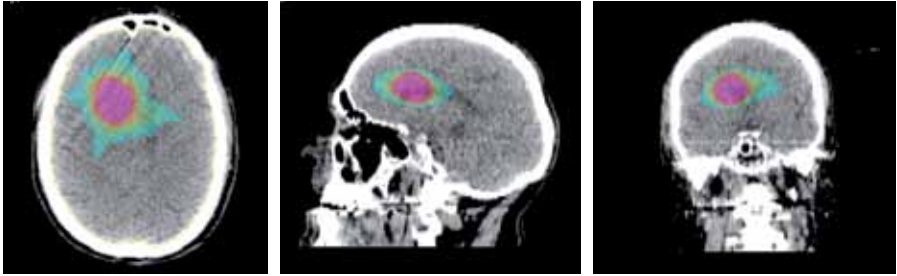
A–C: Radiation plan for the recurrent glioblastoma multiforme shown in Fig. 1, based on the FET PET and MRI scans in Fig. 1 A and B
